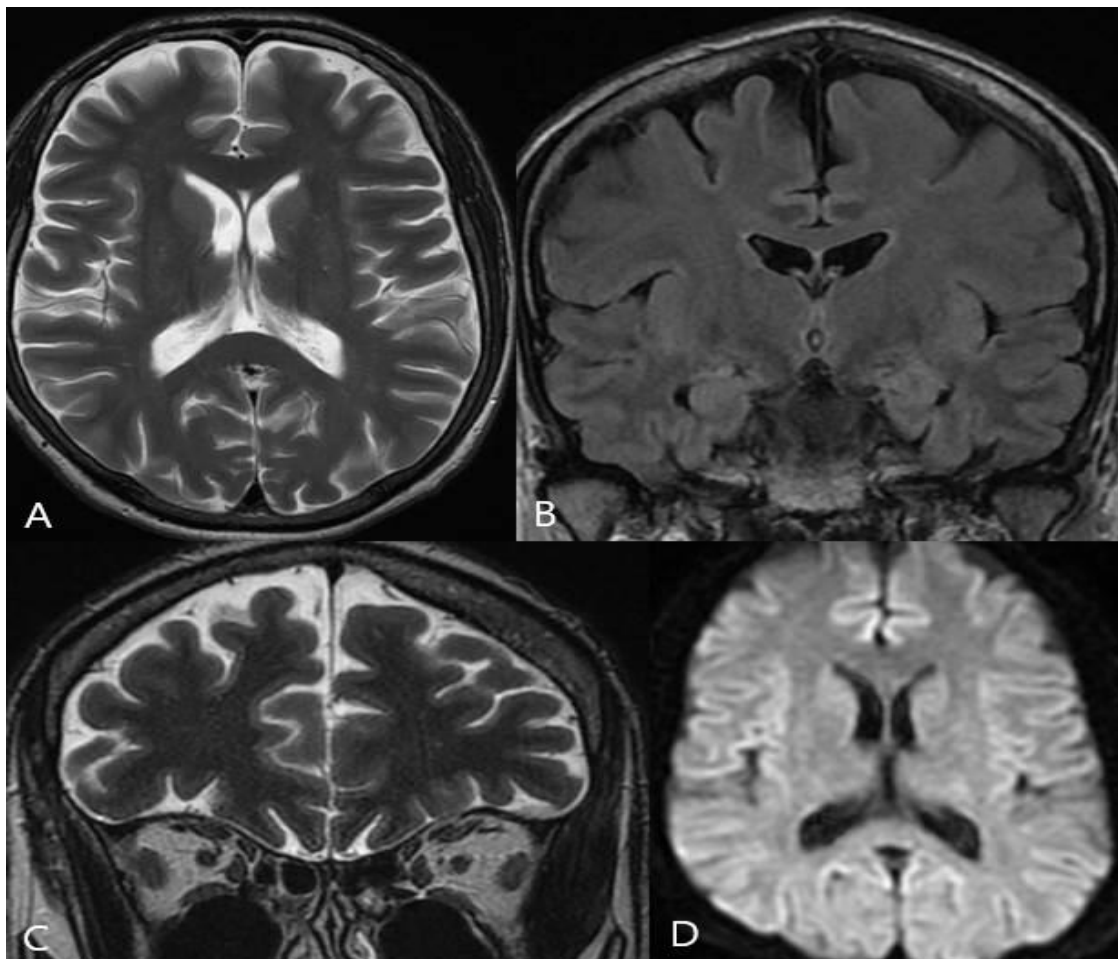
Initial magnetic resonance imaging (MRI) failed to demonstrate any radiological explanation for the mild neurological deficits noted three months after the last embolization session.
